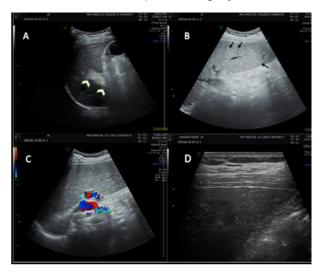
(A) Ultrasound demonstrates periportal echogenicity (white arrow heads) along main portal vein its right and left branches and few segmental branches. (B & C) Spleen is enlarged in size with tiny echogenic foci, Gamma - Gandy bodies (black arrows) and show dilated and tortuous splenic vein. (D) Liver demonstrates normal smooth outline.
